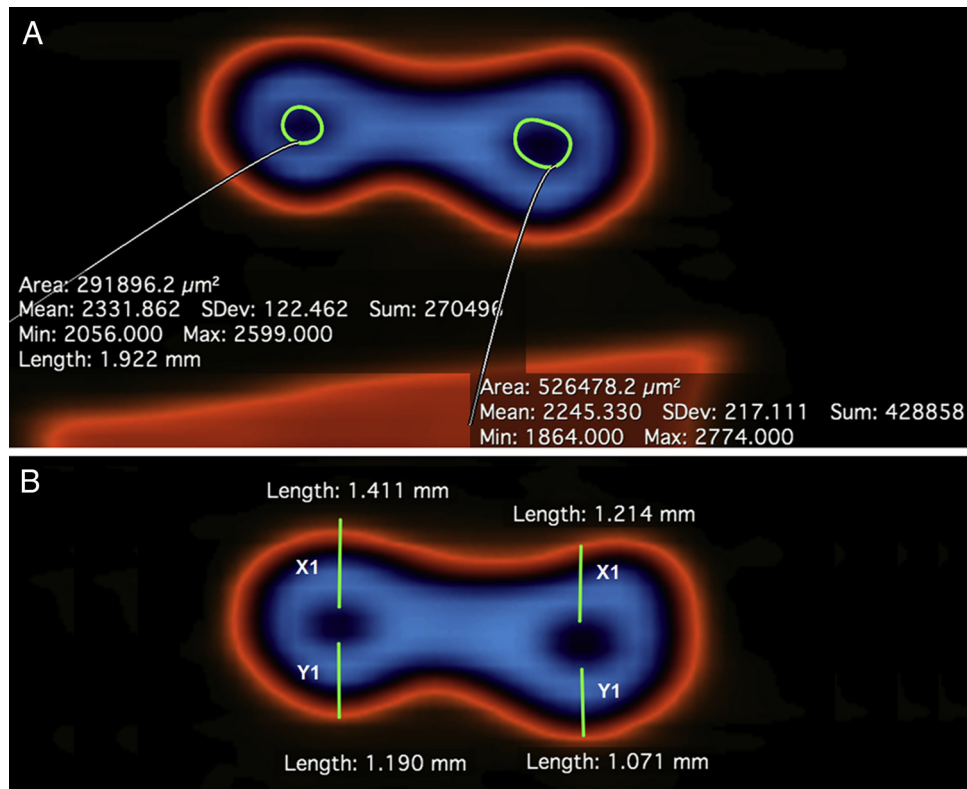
Representative CBCT images of pre-instrumented canals visualized in the Osirix MD software. (A) Root canal area outlined in green to determine its limit. (B) Measurement of apical transportation made before mesial root canal preparation to be applied in the formula $D = (X1 - X2) \times (Y1 - Y2)$.
